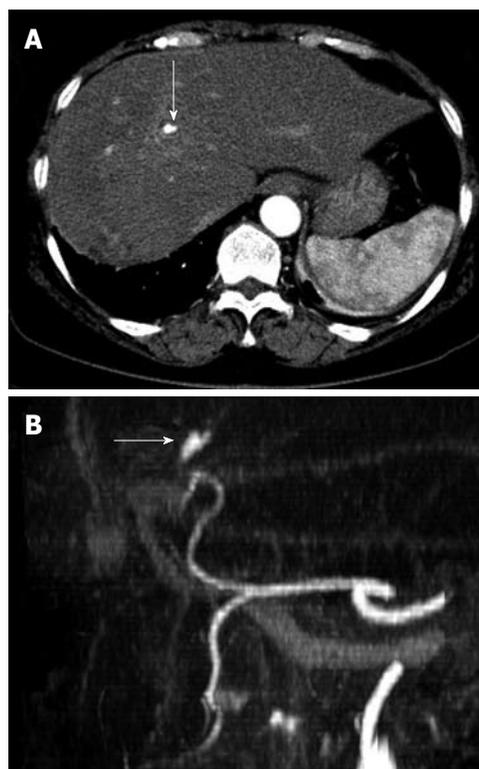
Follow up of abdominal computed tomography scan (A) due to abruptly aggravated abdominal pain and reconstructed computed tomography angiogram (B) showed newly developed hepatic artery pseudoaneurysm in the left lateral segment of liver (white arrows).
